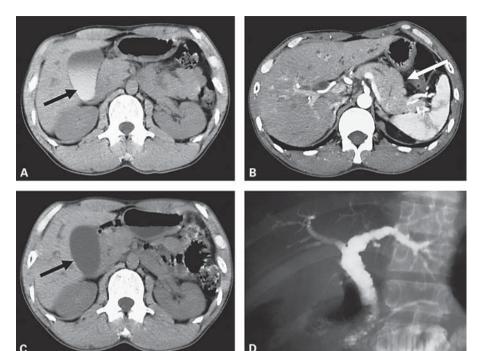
A Plain CT scan showing limy bile in the gallbladder (black arrow). B Contrastenhanced CT scan showing swollen pancreas with homogeneous parenchyma (white arrow). C Plain CT scan showing complete disappearance of limy bile (black arrow). D Endoscopic retrograde cholangiogram showing biliary strictures and diverticulum-like outpouching. No gallstones were detected in the choledochus.
